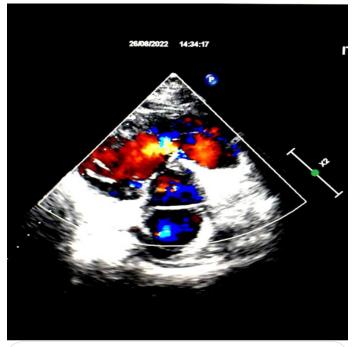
Echocardiography, incidence parasternal short-axis, color doppler with aliasing indicating intra-RV obstruction.
